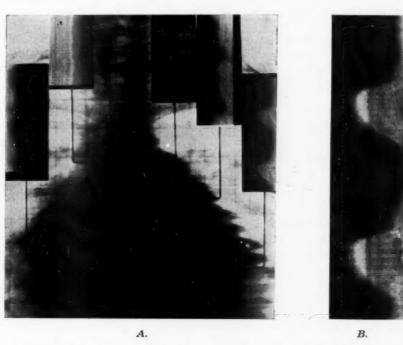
Mitral stenosis and incompetence complicated by atrioventricular block. A, Analytic roentgenkymograms recorded on the mid-portion of the left ventricle, the left middle arch, and the right lower arch. B, Kymoanalytic tracing (natural size) showing the trapezoid pattern of the left ventricle.
